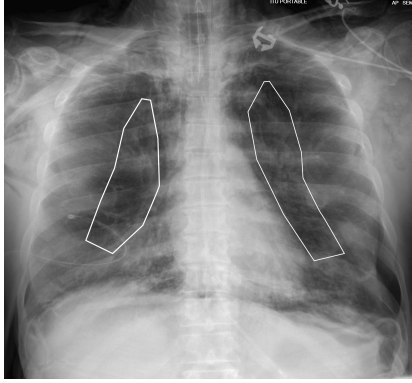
Sample annotation of Chest X-Ray (CXR) image that has been affected with the regions showing presence of pneumonia that could be Covid-19 as annotated by a radiologist
